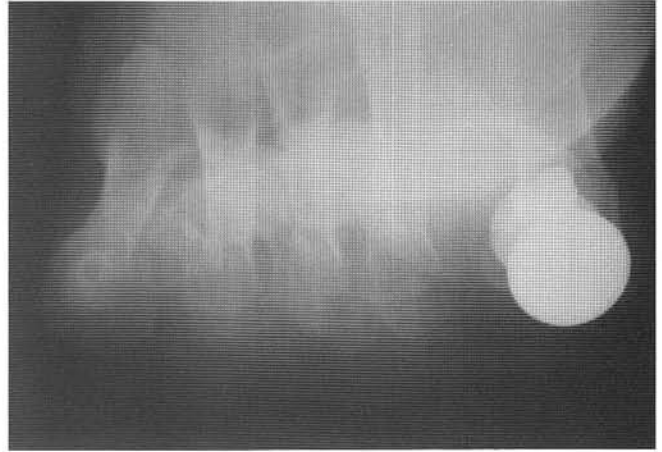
Postoperative x-ray after sesamoid removal using the ReFlexion™ implant.
